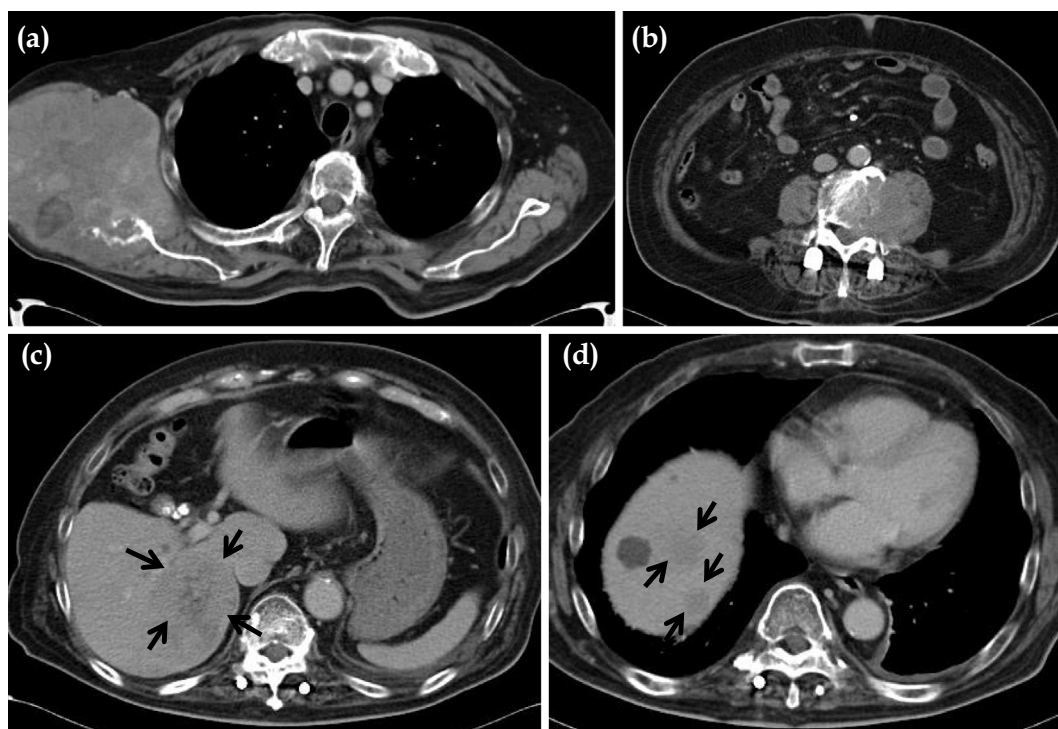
(a) Contrast-enhanced CT showing the lesion of the right shoulder, (b) the tumor in the para vertebrae portion, and (c, d) multiple intrahepatic hypovascular nodules (arrows).
